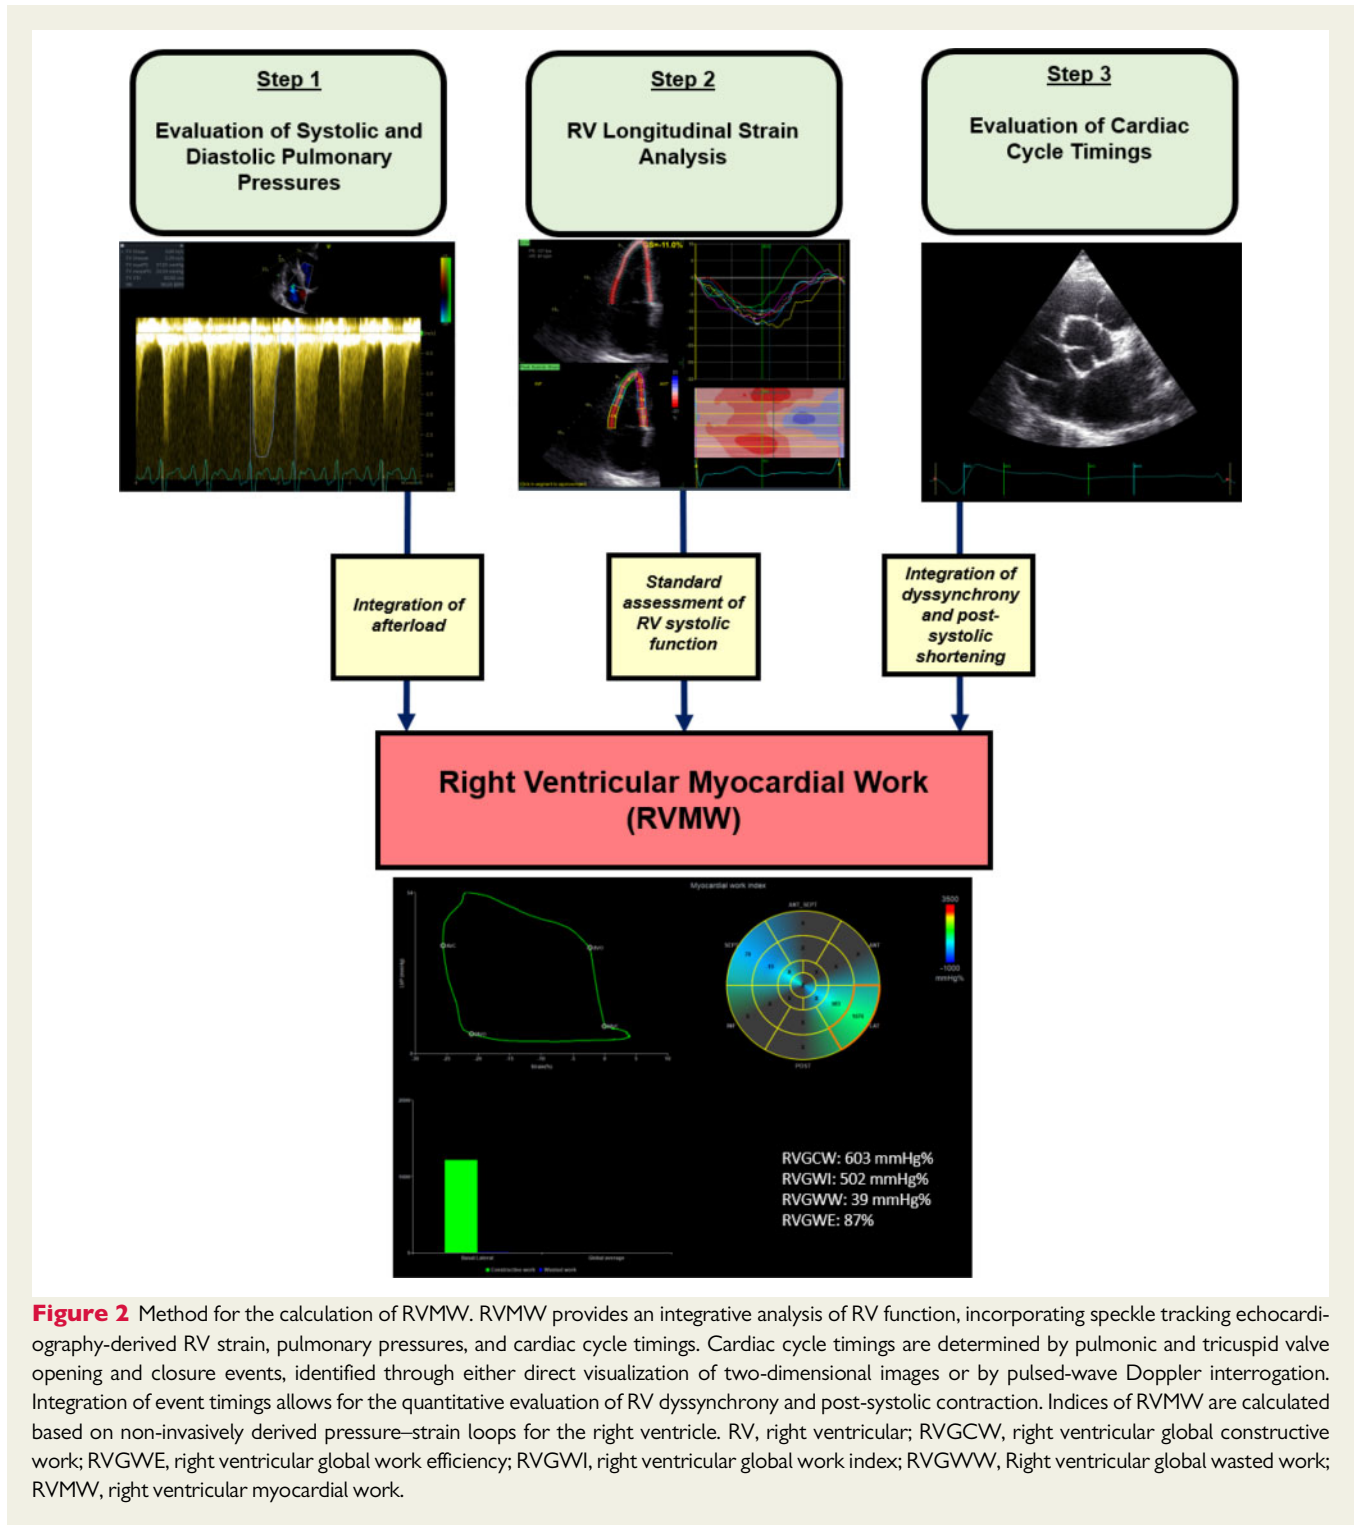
Method for the calculation of RVMW. RVMW provides an integrative analysis of RV function, incorporating speckle tracking echocardiography-derived RV strain, pulmonary pressures, and cardiac cycle timings. Cardiac cycle timings are determined by pulmonic and tricuspid valve opening and closure events, identified through either direct visualization of two-dimensional images or by pulsed-wave Doppler interrogation. Integration of event timings allows for the quantitative evaluation of RV dyssynchrony and post-systolic contraction. Indices of RVMW are calculated based on non-invasively derived pressure–strain loops for the right ventricle. RV, right ventricular; RVGCW, right ventricular global constructive work; RVGWE, right ventricular global work efficiency; RVGWI, right ventricular global work index; RVGWW, Right ventricular global wasted work; RVMW, right ventricular myocardial work.
